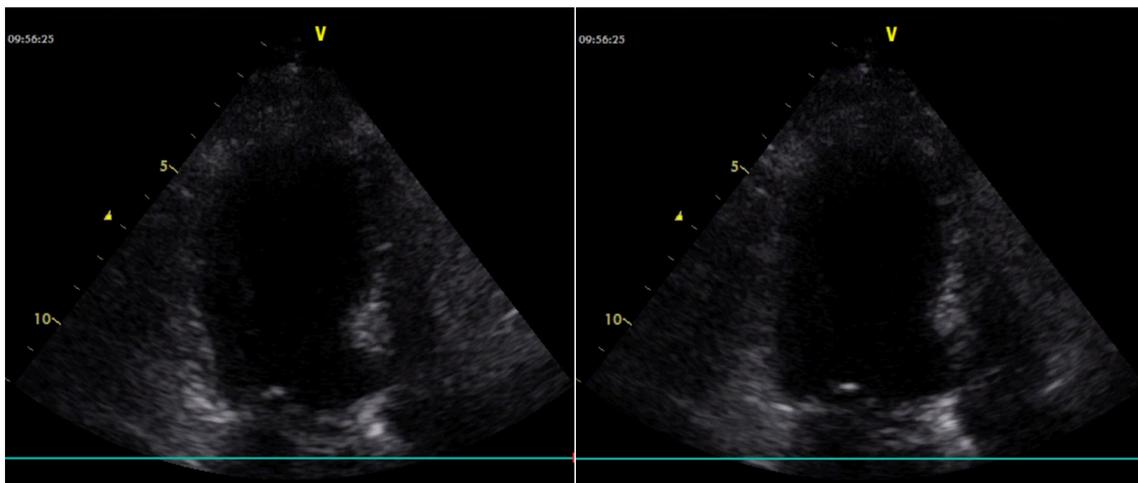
Echocardiography showing circumferential akinesis of the mid and apical segments of the left ventricle with moderately decreased global systolic left ventricular function. (Apical four chamber view of the left ventricle. Left side: systole, right side: diastole.)
